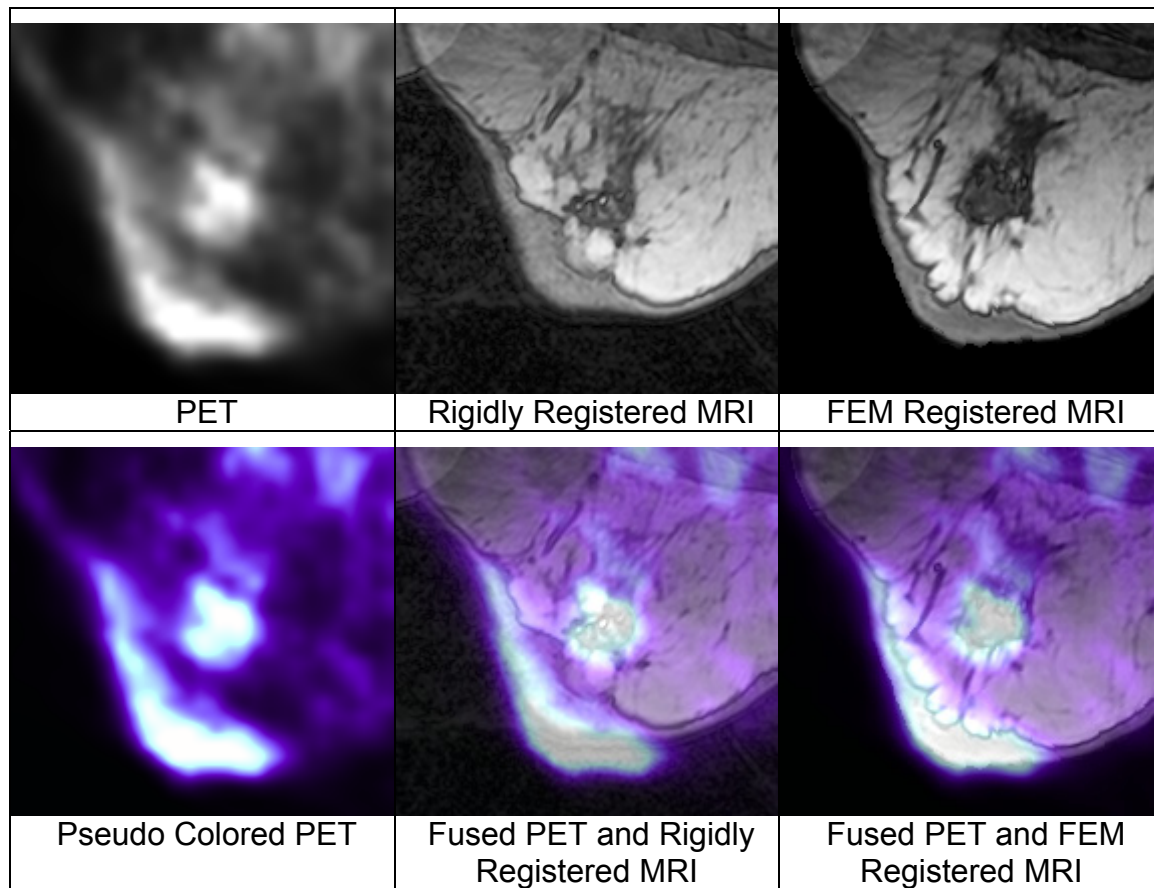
Second example demonstrating the improvement of FEM registration over rigid registration. Original PET image (top left), MRI image after rigid registration (top middle), MRI image after FEM registration (top right), pseudo colored PET image (bottom left), fused pseudo color PET image and MRI image after rigid registration (bottom middle), and fused pseudo color PET image and MRI image after FEM registration (bottom right). Improvements in registration can be seen along the skin surface and at the areas of higher activity within the body of the breast. Look up tables used to pseudo color PET image and fuse MRI and PET images are shown in Figure 2.37 and Figure 2.38, respectively.
